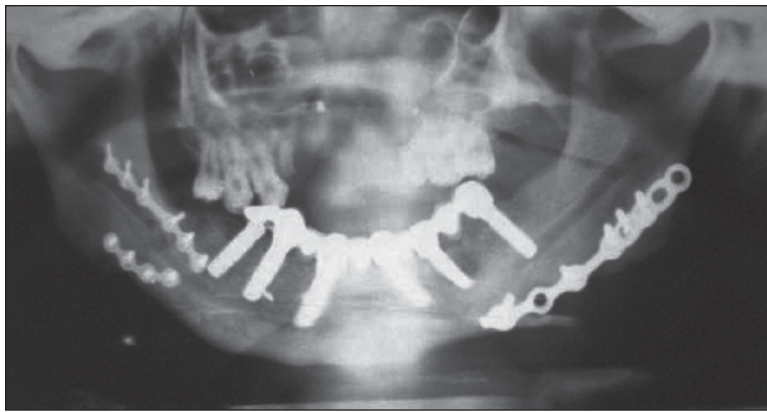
Radiographic view of mandibular rehabilitation with symphyseal bone grafting and osseointegrated dental implants.
